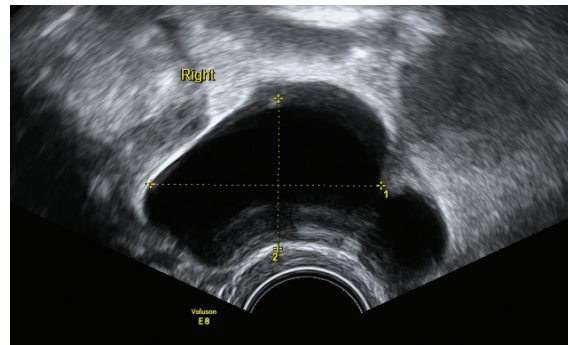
Hydrosalpinx at ultrasound. Courtesy of Esther Westen
